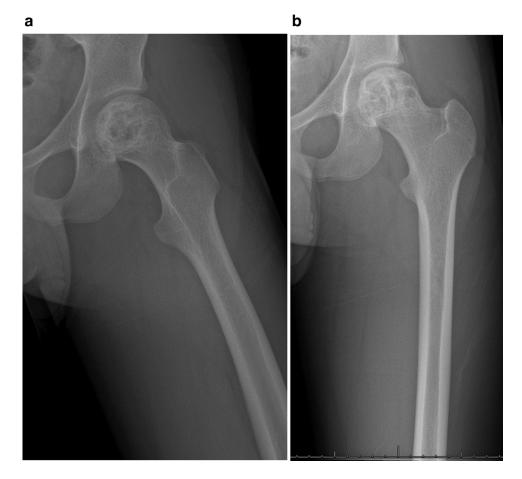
Proximal femur AP (A) and lateral (B) radiograph 3 months from diagnosis and postsystemic treatment demonstrating increasing resolution of the previously noted cystic areas within the proximal femoral epiphysis.
